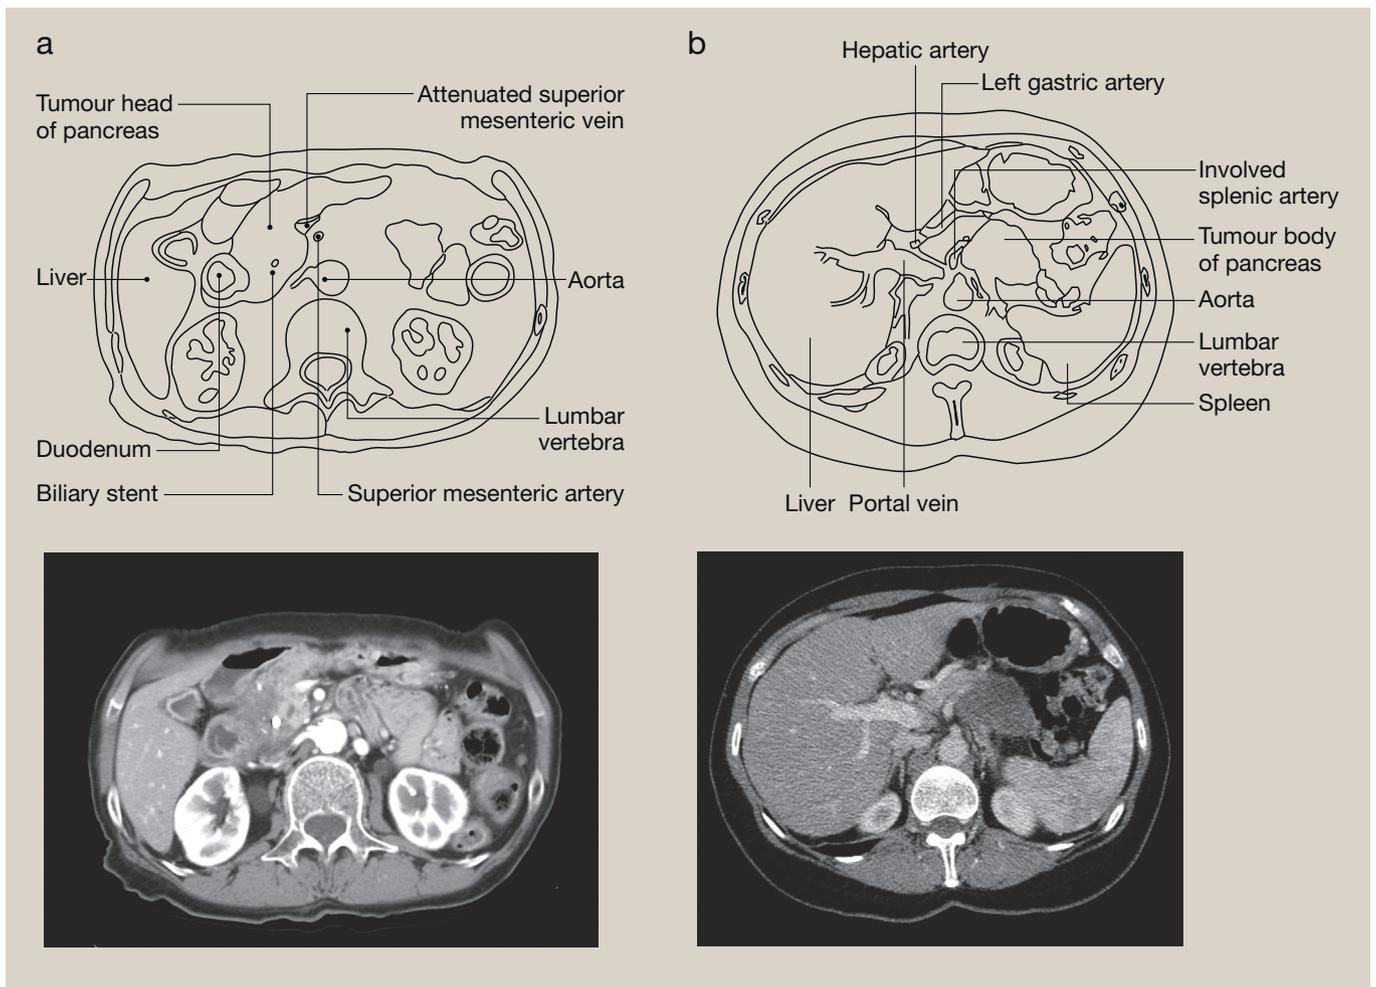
(a) CT scan showing a tumour of the head of pancreas involving the superior mesenteric vein. A plastic biliary stent previously inserted for obstructive jaundice is clearly visible. (b) CT scan showing a tumour of the body of the pancreas involving the splenic artery. Although the left gastric and hepatic arteries can be seen in close proximity, they are not involved and the tumour is resectable.
